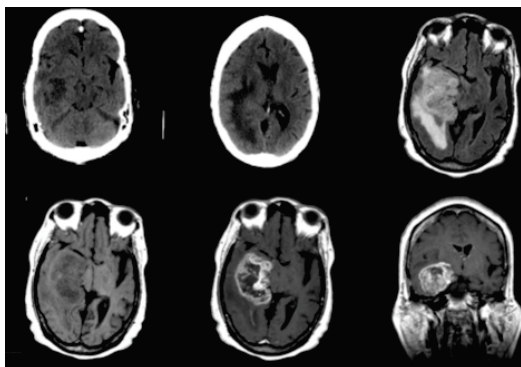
Grade IV astrocytoma. Nonehanced CT Image and fluid-attenuated inversion recovery (FLAIR) MAI
